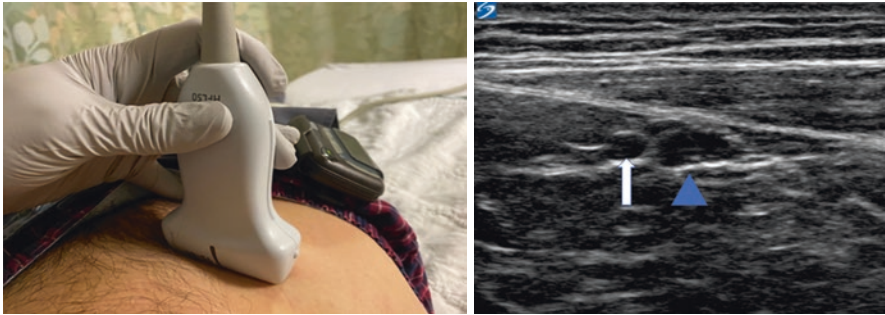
Genitofemoral Nerve Block (Genital Branch) in male. Probe and needle orientation, on the left. Ultrasonogram, on the right. Blue Arrowhead—Spermatic Cord
